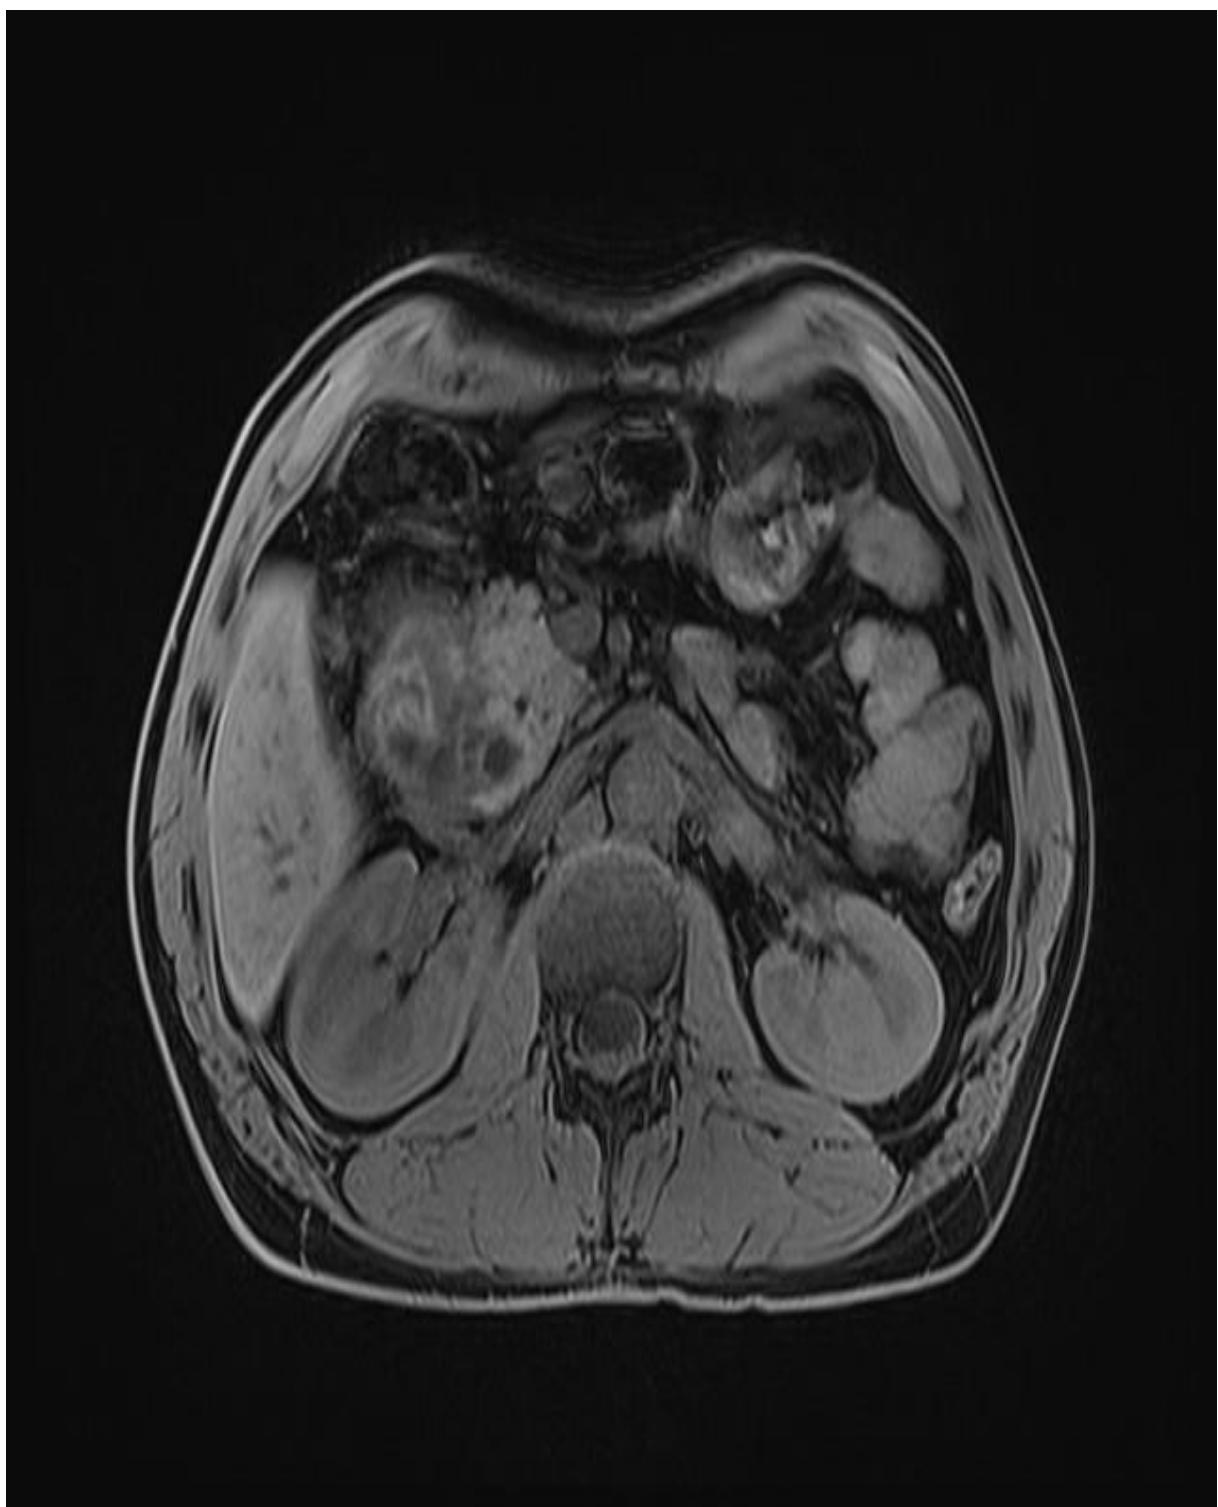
&2 MRI showing stenotic duodenum and cyst distributed around its lumen and groove region with ongoing inflammation
